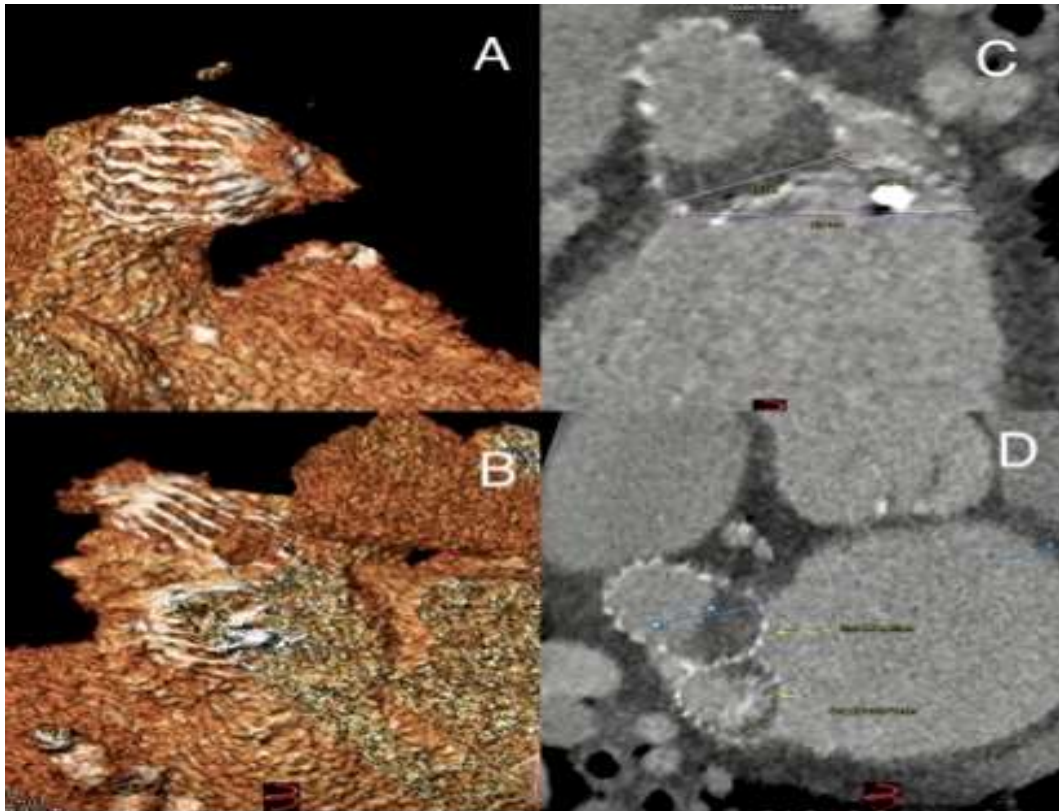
Computed tomography (CT) images. A and B: 3D reconstruction to verify the anatomical relationship. C and D: CT slice to confirm the correct position of the two devices.
